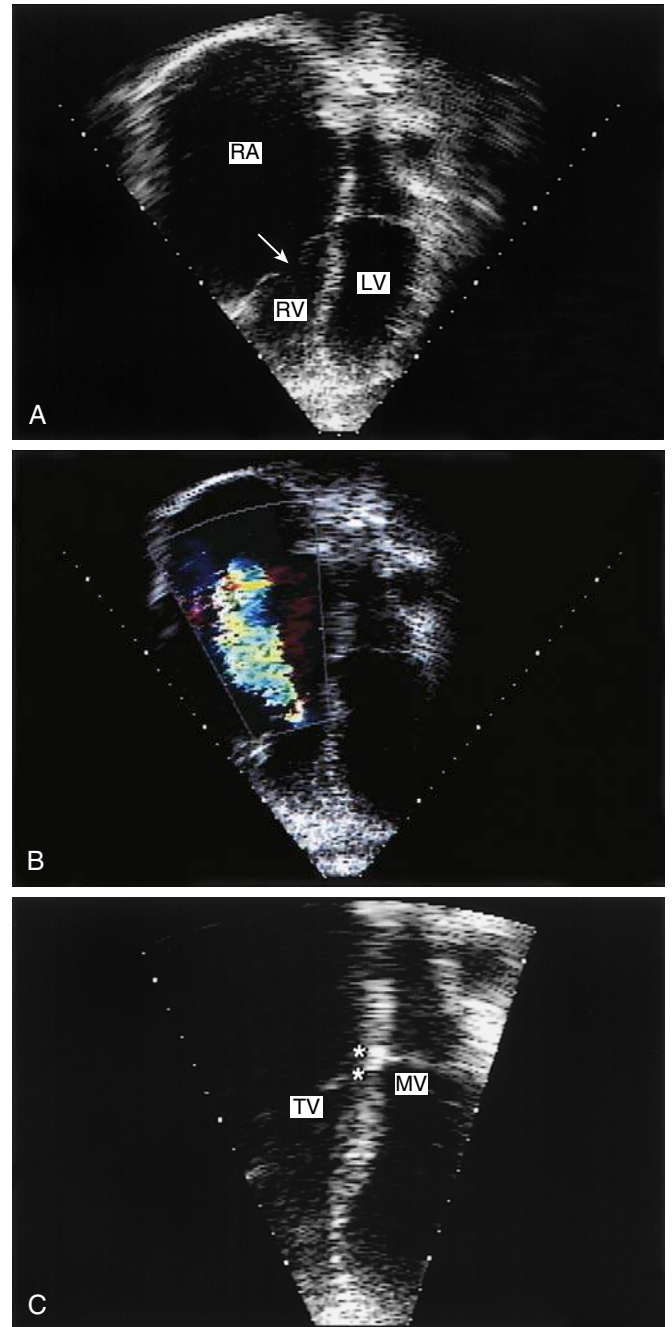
Echocardiograms (from the apical four-chamber view) of a 34-year-old man with tricuspid valve dysplasia. A, Underdeveloped leaflets tethered to the septum and free wall of the right ventricle (RV), with secondary incomplete coaptation (arrow) and tricuspid regurgitation. B, As seen on color flow Doppler imaging. C, Displacement index of the septal leaflet of the tricuspid valve (TV) of 8 mm or 6 mm/m², consistent with non-Ebstein anomaly of the tricuspid valve. LV, Left ventricle; MV, mitral valve; RA, right atrium.
